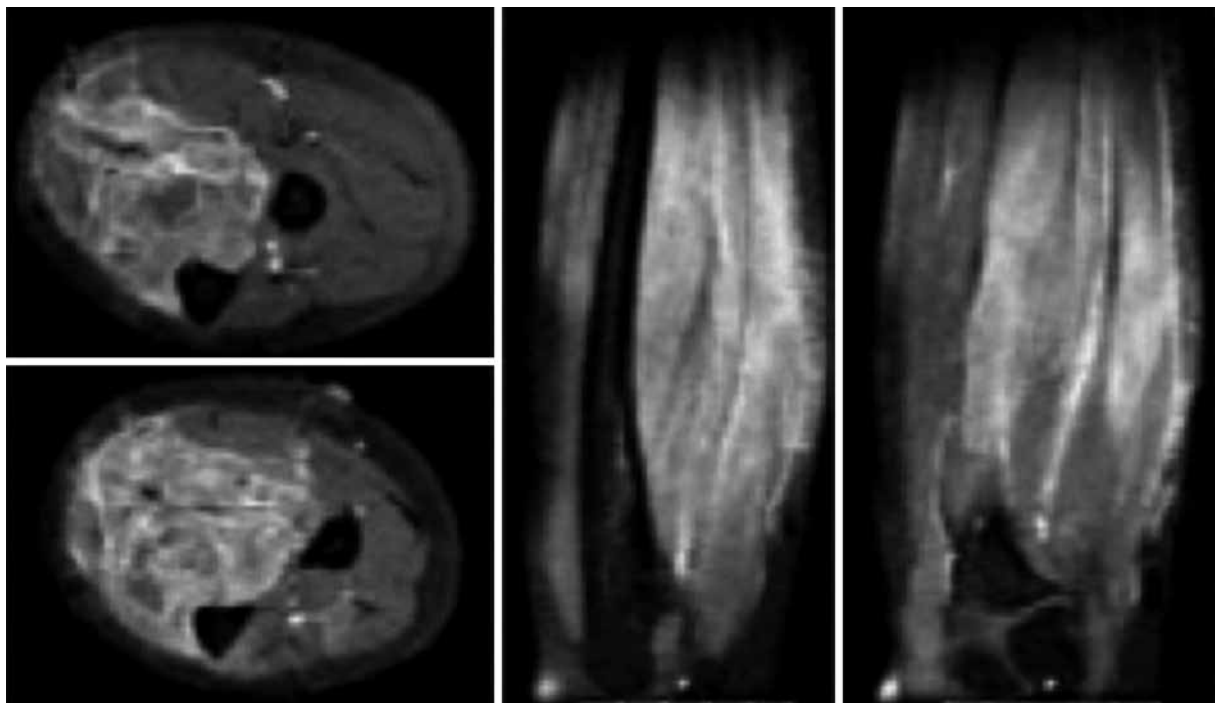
MRI of right forearm: diffuse hyperintensity of the forearm flexor muscles, including the superficial and deep compartments, extending along the corresponding myotendinous joints with intense muscle uptake of gadolinium.
